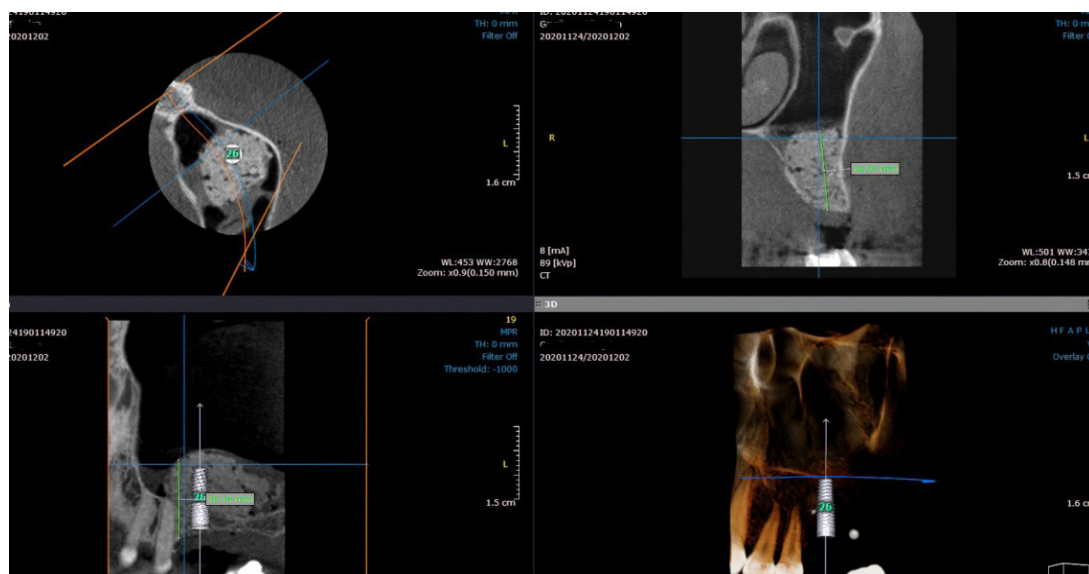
Postoperative CBCT evaluation of the anterior bone height after using xenograft material, having the distal surface of the adjacent tooth as a landmark.
